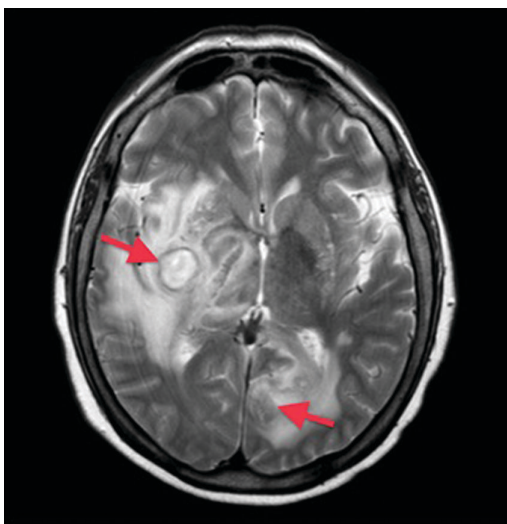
T1 weighted brain MRI image demonstrating right insular/basal ganglia and left occipital lesions, and surrounding edema.
